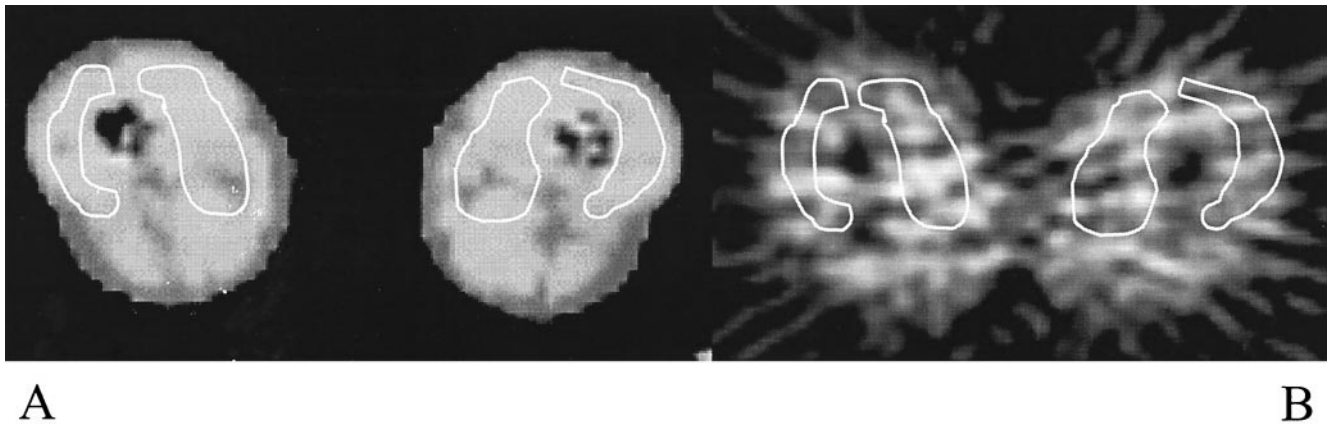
ROIs were identified on the medial and lateral thigh muscles on the coregistered CT-transmission scan (A) and then applied to dynamic PET images (B).
